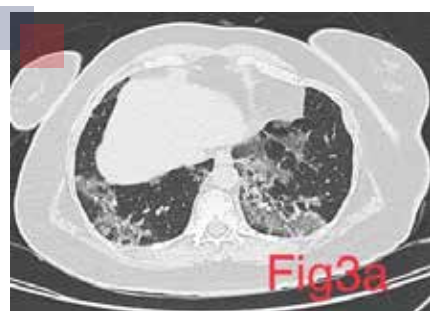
CT Chest showing Bilateral lower lobe patchy ground glass opacities
